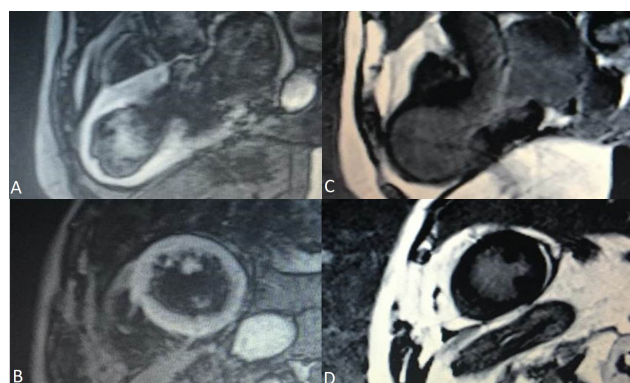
Cardiac Magnetic Resonance Imaging of a 78 years old female patient in the acute phase of Takotsubo Syndrome. Myocardial edema can be observed in the apical regions of the left ventricle in T2 weighted images (A and B) and the lack of late gadolinium enhancement in C and D.
